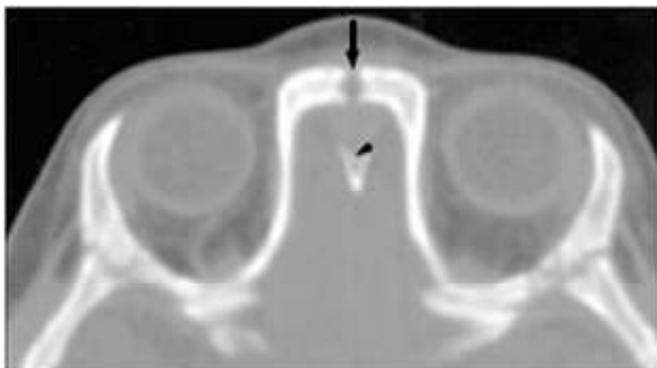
CT scan shows separated nasal bone (Arrow) and wide foramen caecum (Arrowhead)
